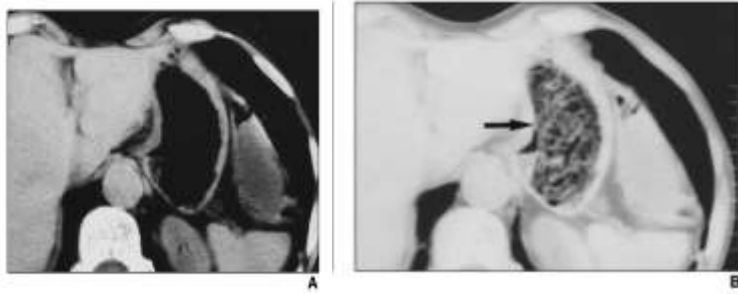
A, CT scan attained at routine abdominal soft-tissue window and level settings (level, 35 H; window, 200 H). Note that it is not possible to detect gastric bezoar. B, CT scan of the same region attained with a level of -119 H. Note that the characteristic of bezoar (arrow) is easily identifiable, ovoid mass extending into the stomach with an inhomogeneous mottled appearance.
